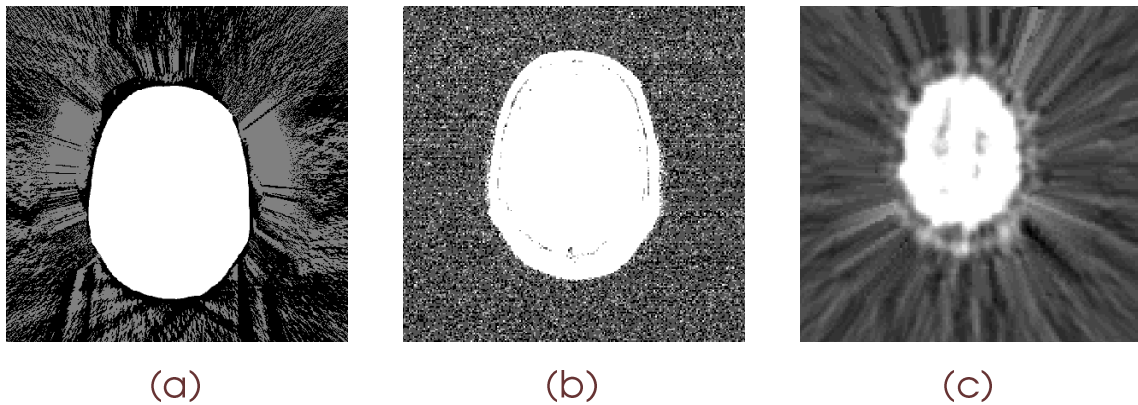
Image volumes after reconstruction of the background in R : (a) CT, (b) MR, and (c) PET.
